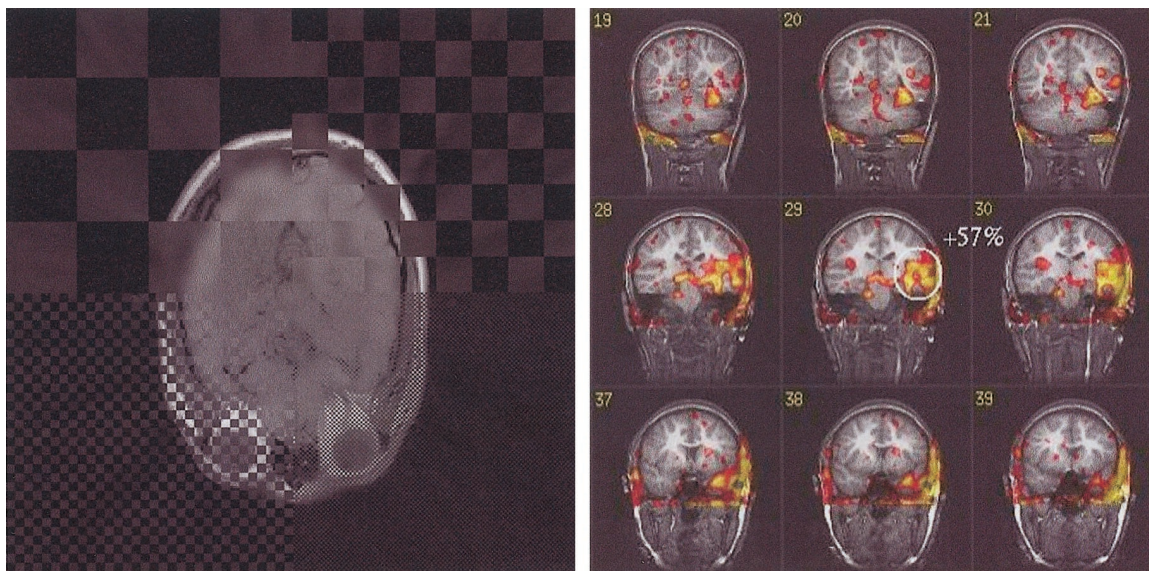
2D fused display. (Left) Checkerboard display of an MR and a SPECT image. The size of the checkers goes from large (left top) to small (right bottom). (Right) Color fusion display of SPECT perfusion increases during a seizure combined with the corresponding MR images for an epileptic patient with a focus in the left temporal lobe.
